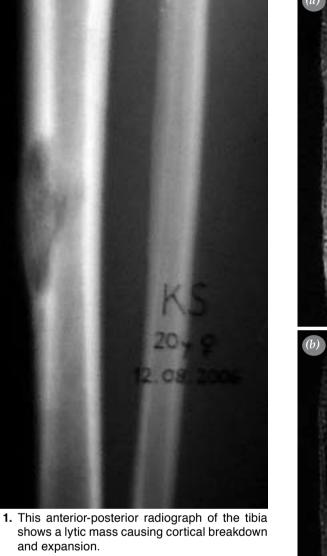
This anterior-posterior radiograph of the tibia and expansion.
